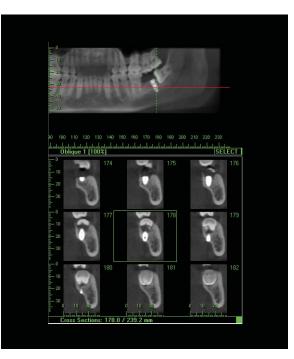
These 3-D images and CBCT cross-sectionals for the same implant site show placement through the undercut. This information is obviously missing on the 2-D images.
